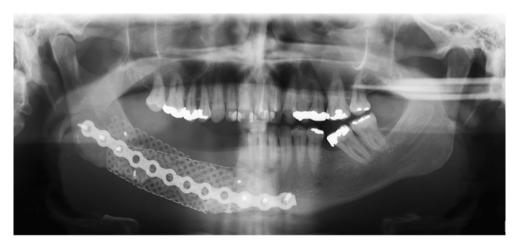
Eleven-month follow-up panoramic radiograph showing bone neoformation.
